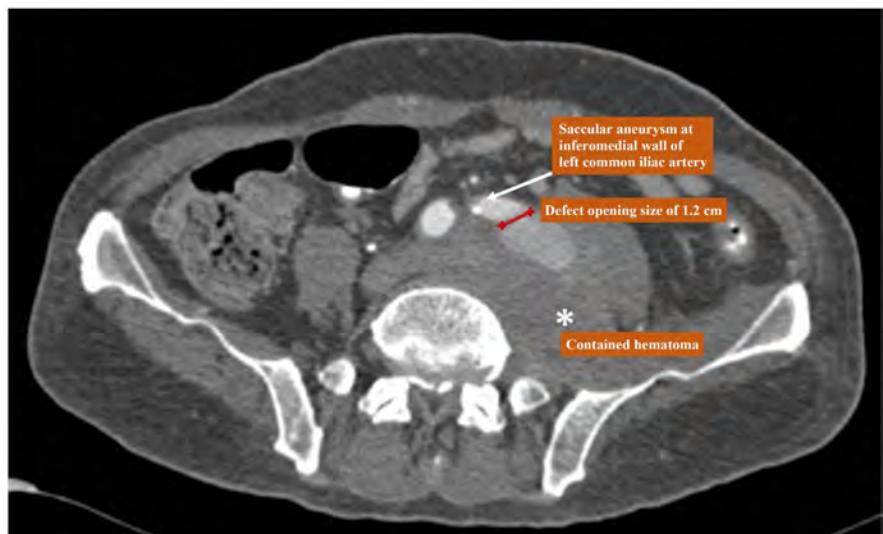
Computed tomography angiography (CTA) of abdomen, axial view shows presence of saccular aneurysm arising from inferomedial wall of left common iliac artery measures $5.7 \text{ cm} \times 7.7 \text{ cm} \times 6.4 \text{ cm}$ (AP \times WT \times CC) with the defect opening measures 1.2 cm in diameter. The area marked with * shows contained hematoma from the aneurysm.
